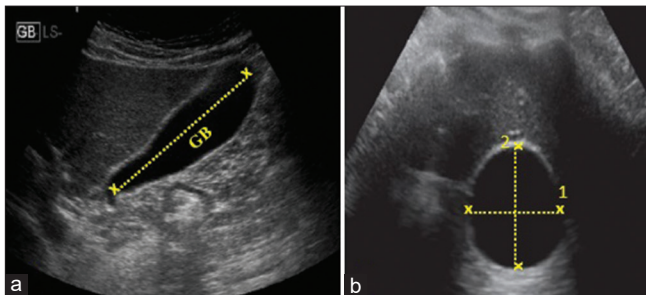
Longitudinal ultrasound measurements of the gallbladder length (a), gallbladder width (b₁) and thickness (b₂). GB: Gallbladder
